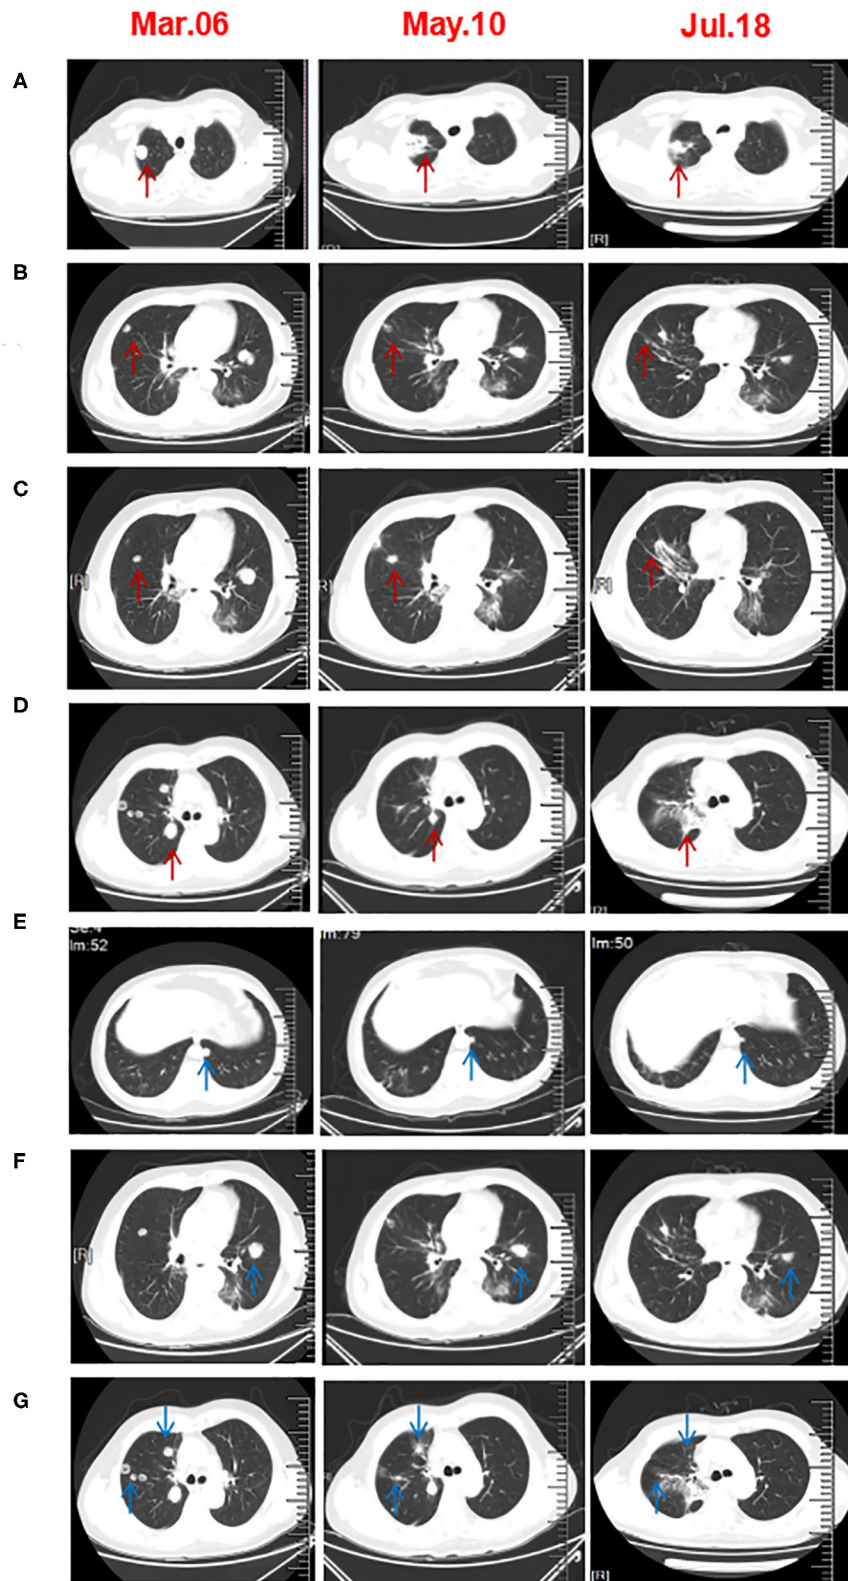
Chest CT scans before and after three cycles of triple-combination therapy and two cycles of sintilimab treatment. (A–D) CT revealed that the irradiated right lung lesions shrunk or even disappeared. The arrow in A is the first lesion of the right lung SBRT. The arrow in (B,C) are the second lesions of the right lung SBRT. The arrow in (D) is the third lesion of the right lung SBRT. (E,F) The unirradiated metastatic lesion of the lung was significantly smaller than that before treatment. (G) After five cycles of treatment, the CT scan showed that the unirradiated lesions in right lung had disappeared.
